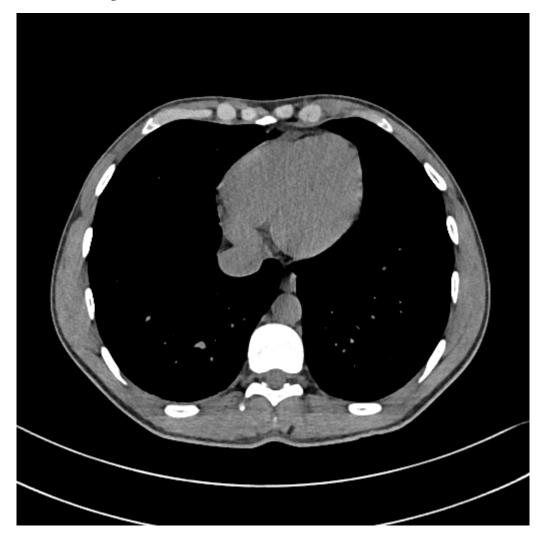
Post-HBO: Chest CT scan w/o contrast medium.
